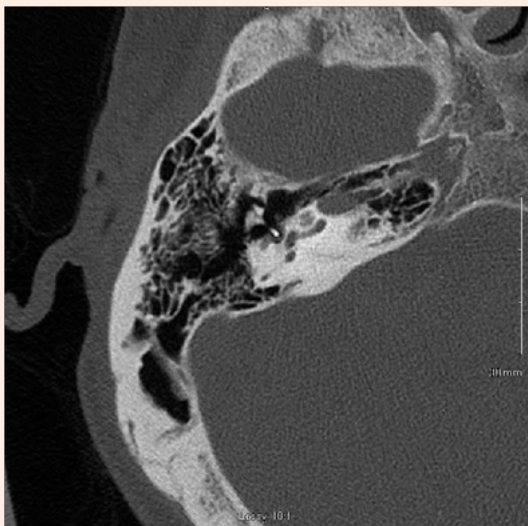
Axial Temporal bone CT. This image depicts the medial-most position of the prosthesis in the axial plane.
